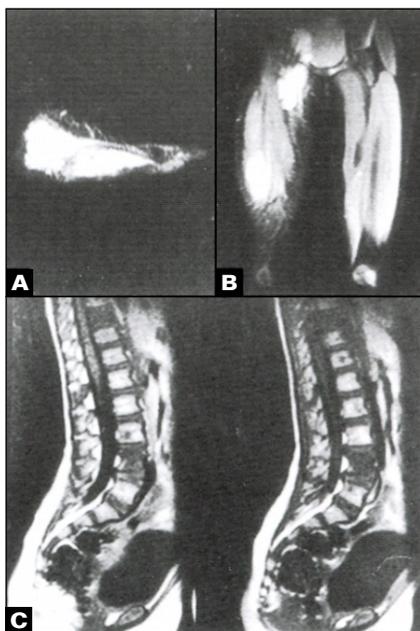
Radiographic appearance of rhabdomyosarcoma. (A) Alveolar rhabdomyosarcoma arising from the plantar surface of the foot. These tumors typically develop in adolescents and are associated with aggressive clinical behavior. (B) Soft tissue metastases in the anterior thigh and inguinal/pelvic region. (C) This patient also had osseous metastases involving numerous vertebral bodies.
